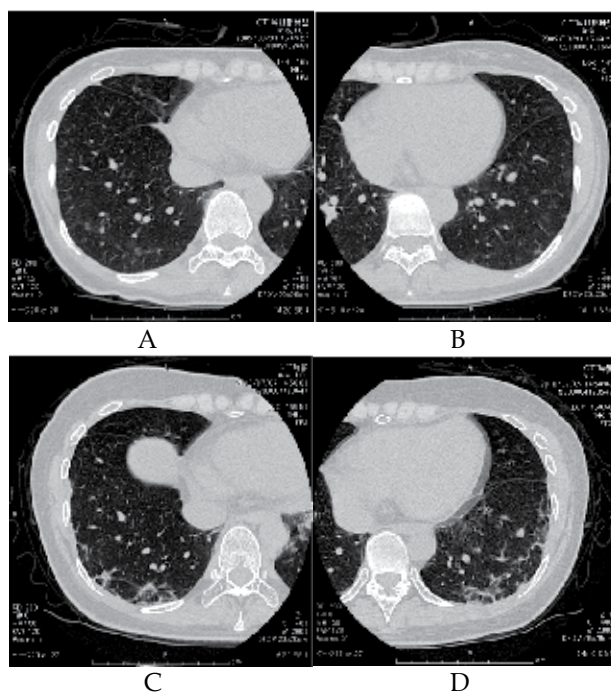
Chest computed tomography of a case with interstitial lung disease associated with clinically amyopathic dermatomyositis with anti-CADM-140 antibody positive. Chest computed tomography on the first admission (A, B) and the second admission about one year later (C, D) indicated progression of interstitial lung disease in spite of daily oral prednisolone 20mg.
